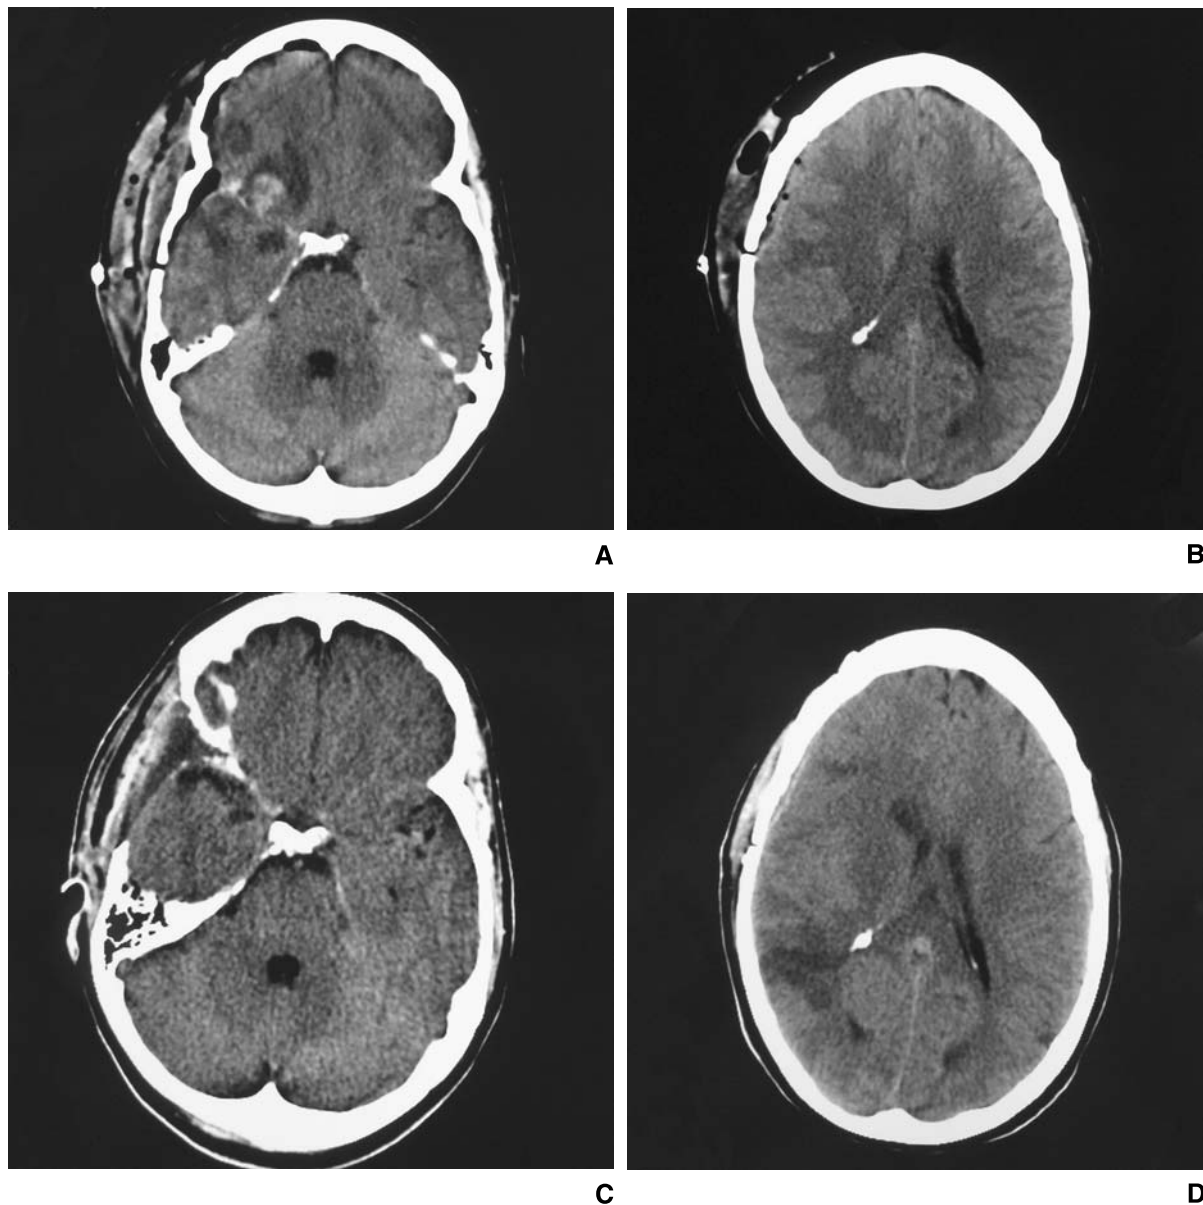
(A) CT scan post-operative day two. Hypointense areas within the right juxta-sylvian brain tissue. On the frontal side there's a small intracerebral haemorrhage. (B) no ischemic lesions can be seen on a more cranial scan. (C) One month after surgery, at the time of delayed vasospasm, the CT show resolution of the juxta-sylvian abnormalities as well as (D) small lacunar infarcts within the right paraventricular white matter
